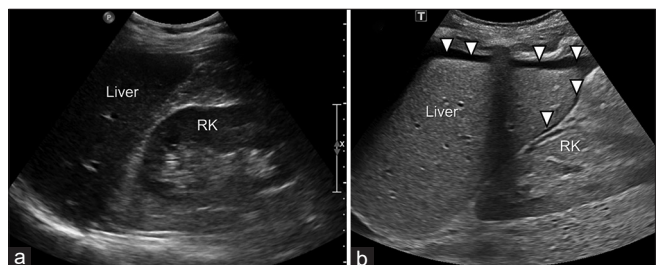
Upper right abdominal quadrant views with (a) absence of free fluid – negative FAST and (b) perihepatic and hepatorenal free fluid (white arrowheads), assumed to be blood in the trauma context – positive FAST. RK: Right kidney, FAST: Focused assessment with sonography for trauma
